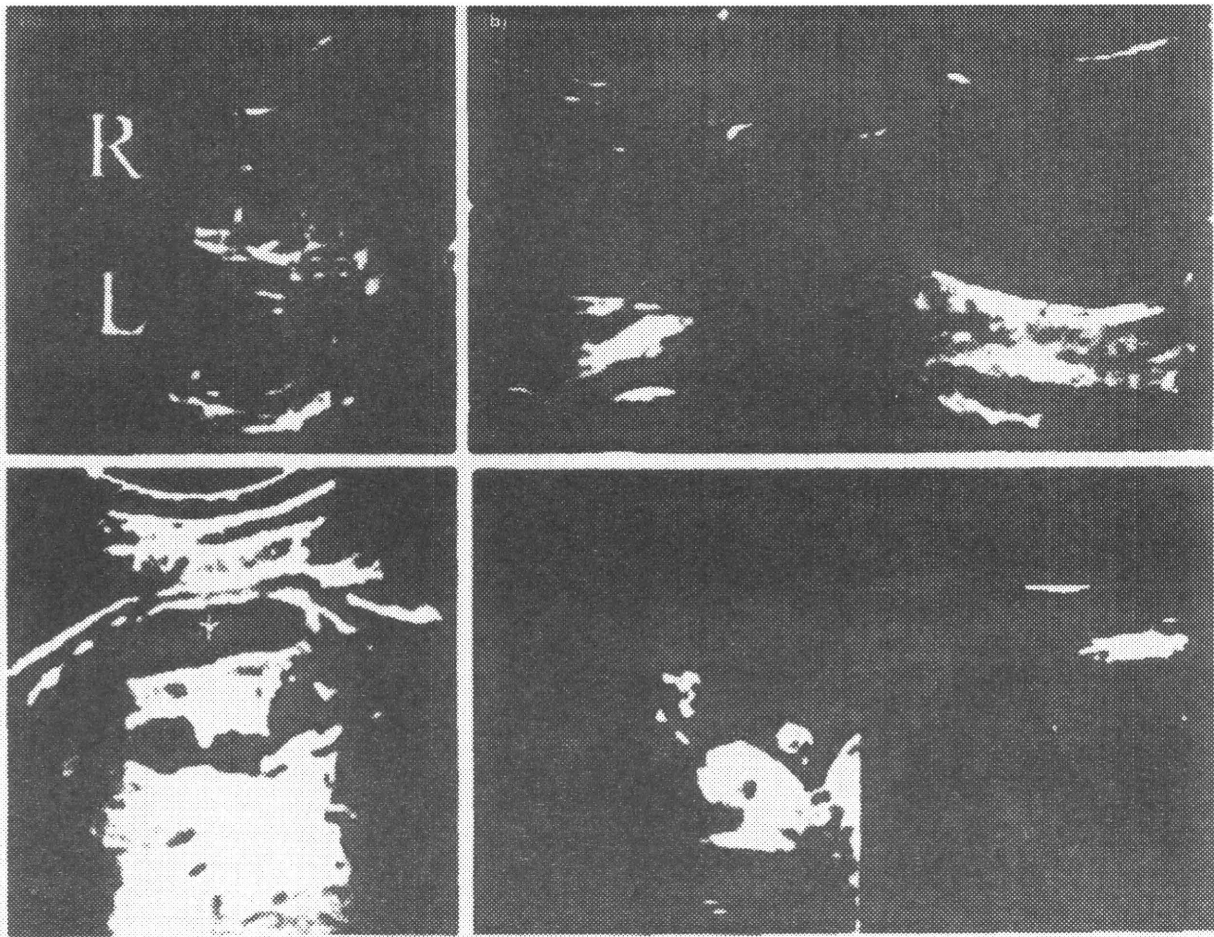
Fetal ultrasonograms. (a) (Before *in utero* shunting) bilateral hydronephrosis was detected. (b) (Before *in utero* shunting) the urinary bladder was enlarged. (c) (After *in utero* shunting) the left urinoma (*) and hydronephrosis showed no change. (d) (After *in utero* shunting) the size of the urinary bladder was markedly decreased. The urinary bladder wall was markedly thickened.
